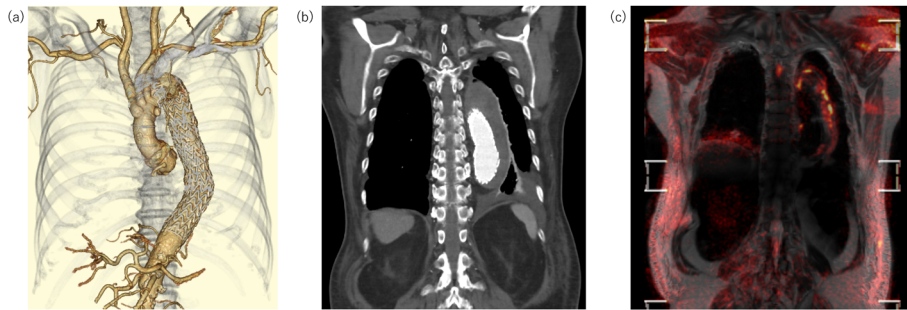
(a) Three-dimensional computed tomography at 3 days after admission. (b) Enhanced computed tomography at 3 days after admission. (c) Whole-body diffusion-weighted imaging with background body signal suppression at 9 days after admission.
